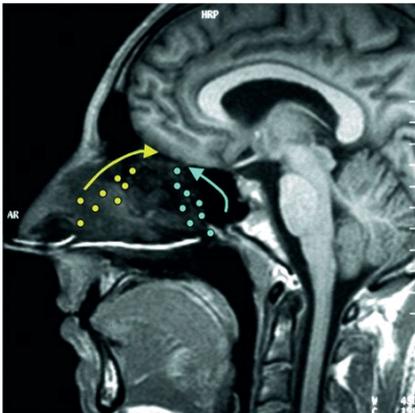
A MRI image showing placement of the nasal cannulae at the external nares, to achieve orthonasal (yellow dots and arrow) and at the retropharynx to achieve retronasal turquoise dots and arrow) odorant delivery. Through the cannulae (white lines in cross-section) odorized air was administrated (1)
